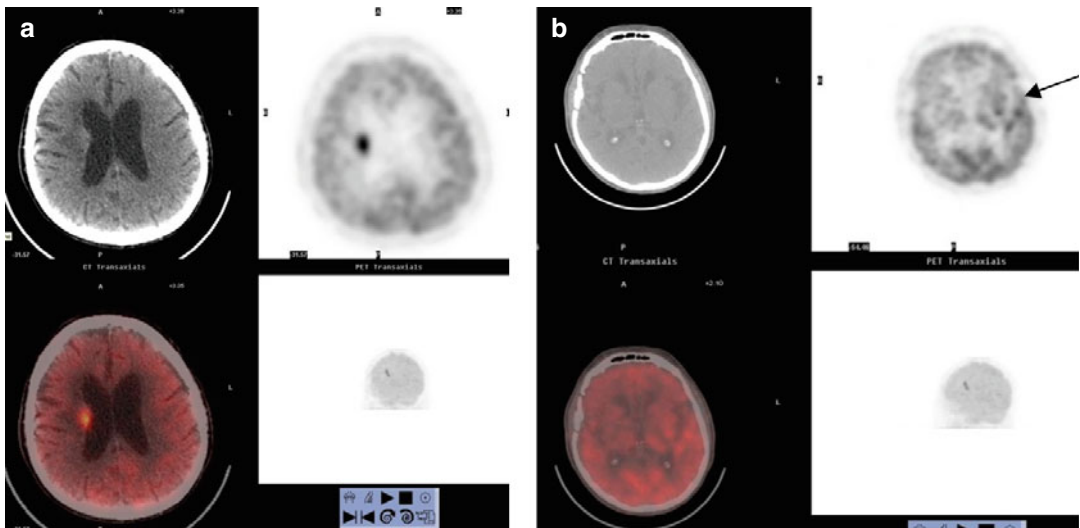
(a) Abnormal FDG uptake is identified in the right periventricular white matter (SUV max 10). (b) Three more foci of abnormal uptake are seen in the left island of Reil and left external capsule (*arrow*)
